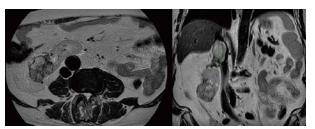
Preoperative MRI of FR-BOD-P*-3611 patient
